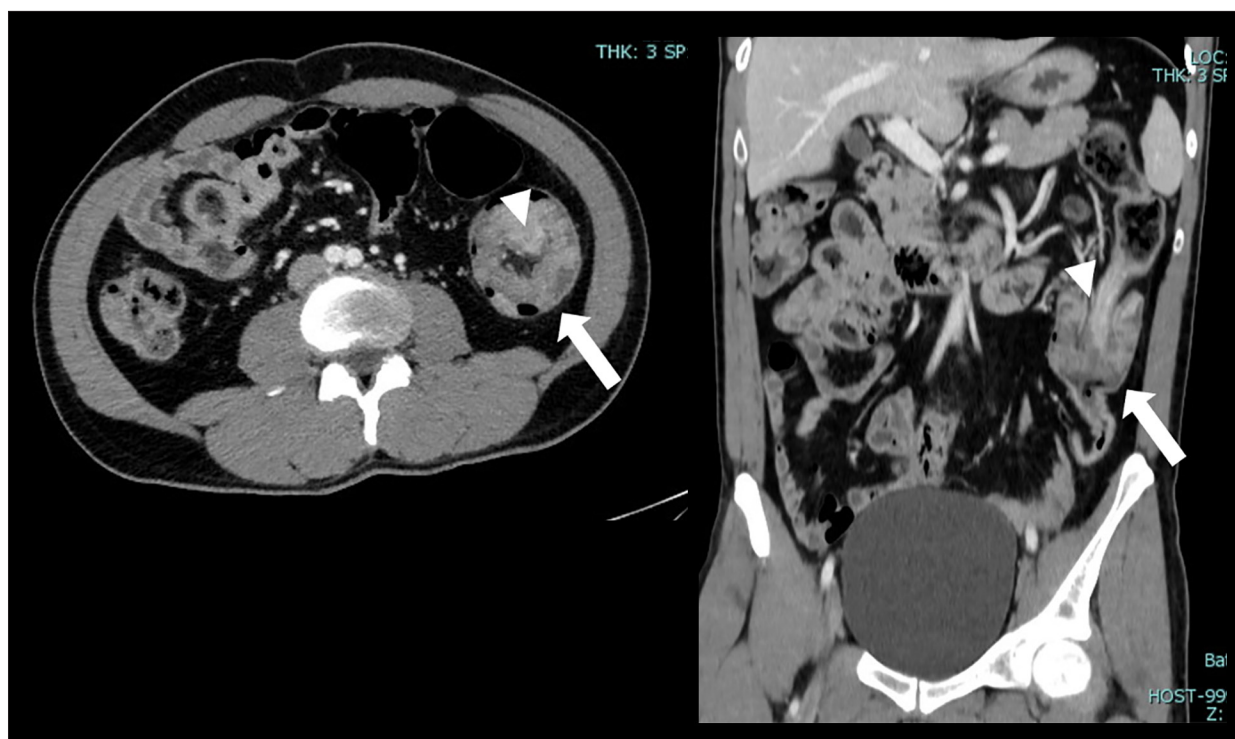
Axial and coronal CT scan with intravenous contrast for a 35-year-old man, demonstrating colocolic intussusception (arrows) just distal to the splenic flexure, with a circumferential wall thickening and a polypoidal mass (arrow heads). The patient had a confirmed diagnosis of colonic adenocarcinoma.
